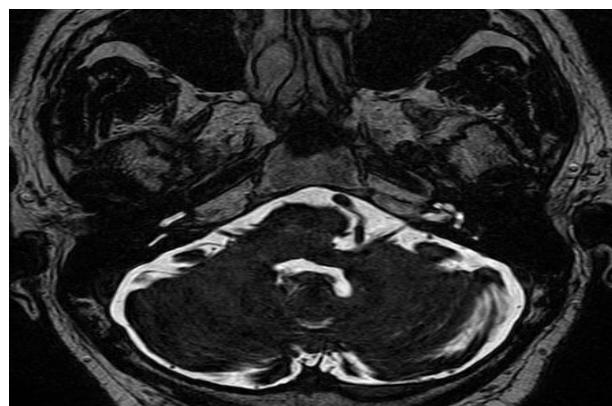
MRI Brain revealed vertebrobasilar Dolichoectasia compressing left facial nerve.
